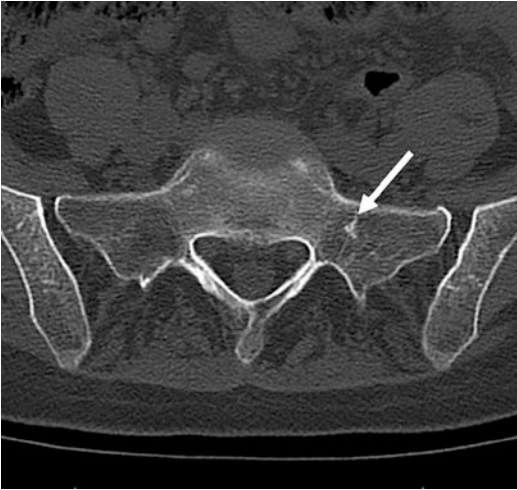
Bone island. Axial CT of the sacrum demonstrates a spiculated lesion in the left sacral ala, which is characteristic of a bone island
